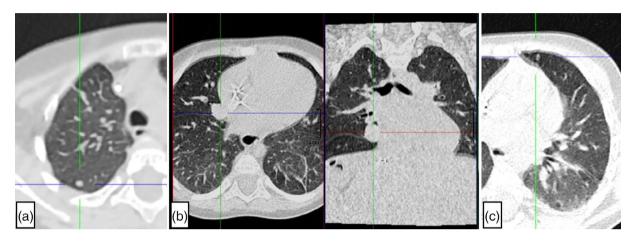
Thoracic CT scan showing several new solid nodular lesions. (a) Subpleural nodule in the upper segment of the right lower lobe. (b) Right paramediastinal nodule in the middle lobe, in contact with the pericardium and the minor cisura. (c) Subpleural nodule located in the area of the lingula in the right lung
